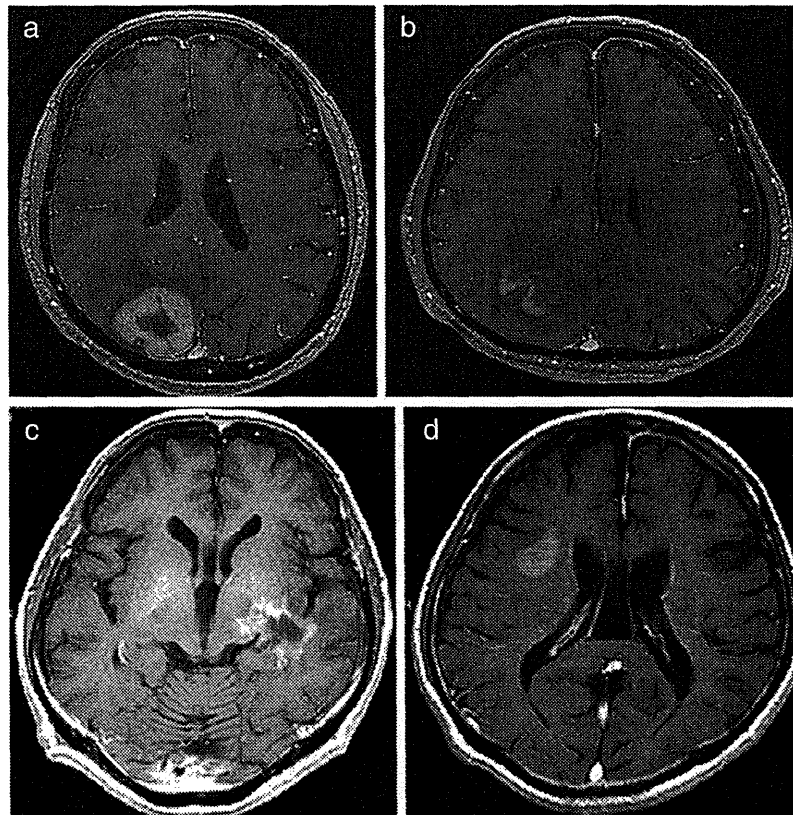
(a) T1-weighted MRI after contrast administration. The lesion has a central, non-enhancing core and possible necrosis in the right occipital lobe (Case 26). (b) T1-weighted MRI after contrast administration. Note the enhancing band-like lesion in the right parietal lobe (Case 27). (c) The initial T1-weighted MRI after contrast administration showing a left temporal lesion (Case 12). (d) Three months later, a newly formed tumor is found in the right frontal lobe on serial MRI (Case 12).
